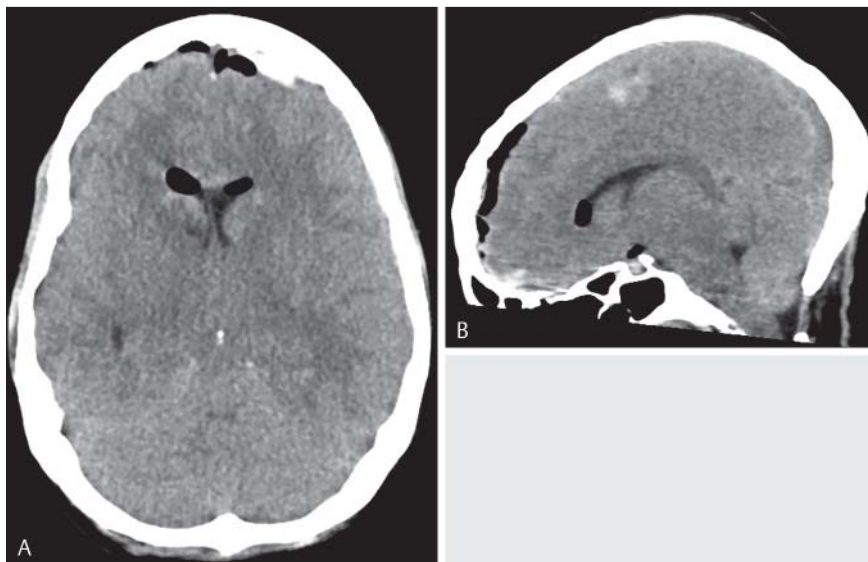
Noch nicht veröffentlichter Fall eines Patienten nach lumbaler, dorsaler Stabilisierung. Nach Anlage einer lumbalen Unterdruckdrainage zeigt das axiale Schädel-CT ein frontales Hygrom rechts A+B und ein Verstreichen der Sulci B. Nach Entfernung der Drainage ist das Kontroll-CT 3 Tage später wieder normal, die Ventrikelweite hat wieder zugenommen C+D.
